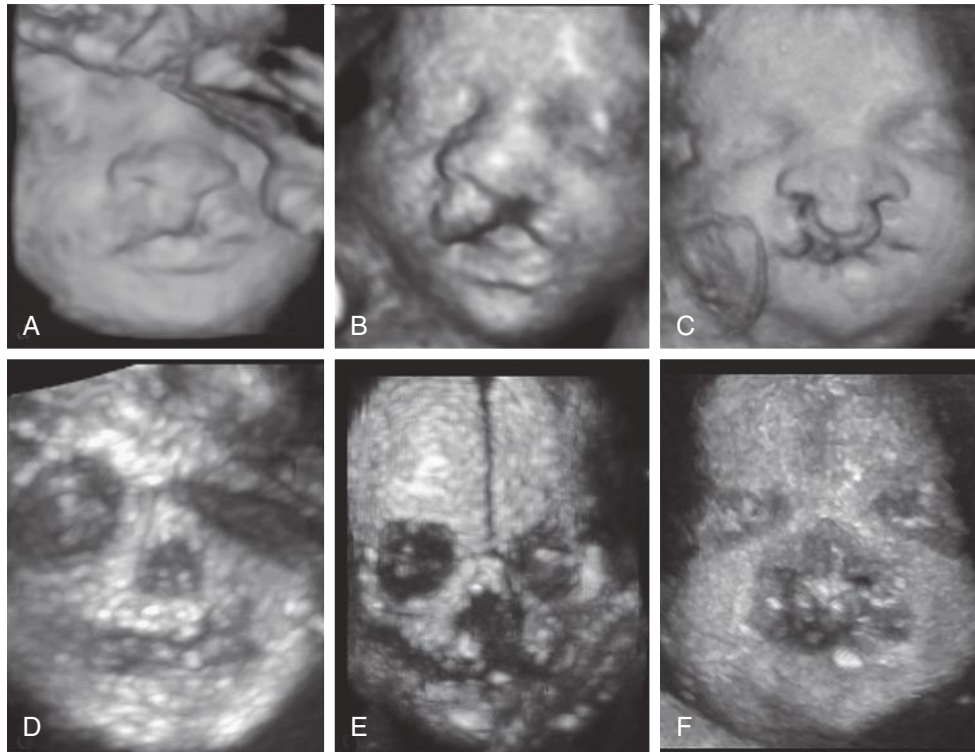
Three-dimensional ultrasound imaging of cleft lip in surface mode (A through C) and maximum mode (D through F). A and D, Unilateral cleft lip. B and E, Unilateral cleft lip and palate. C and F, Bilateral cleft lip and palate.
